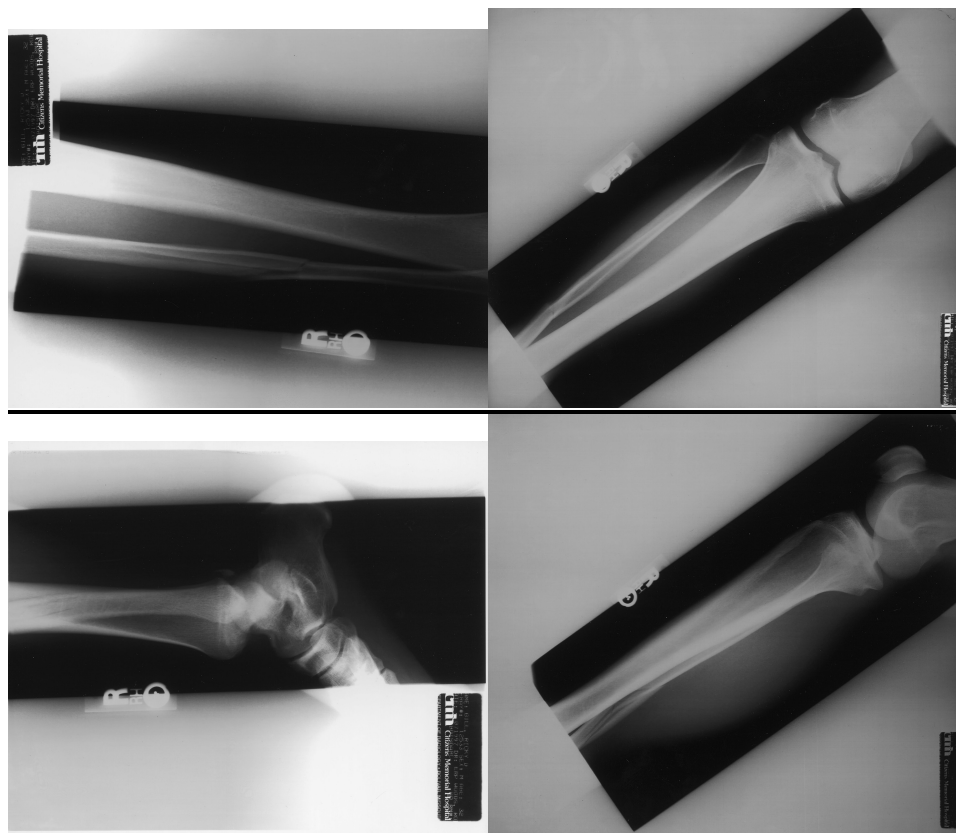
More Radiographs from PWC File 5.
